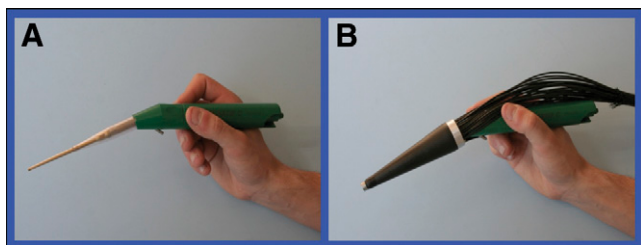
An ultrasonic aspirator (A) is coupled with the intraoperative β -probe (B) in the device seen in Figure 15.
